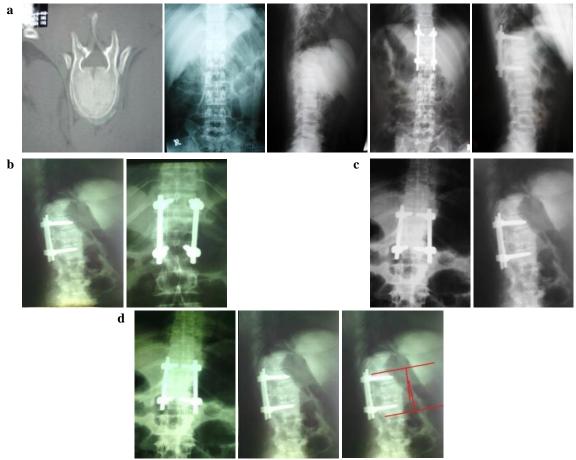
<u>a</u>. Post-operative X-ray, <u>b</u>. after two months, <u>c</u>. after four months, <u>d</u>. After six months
